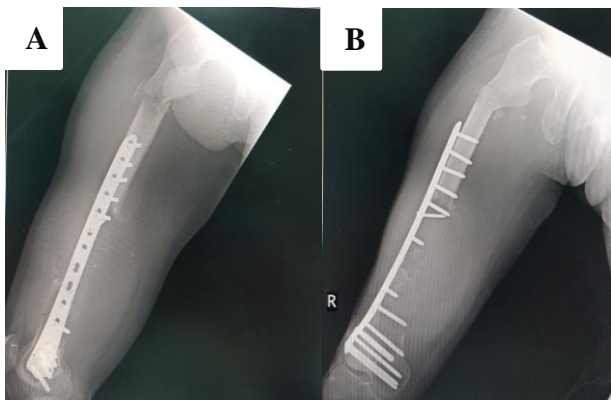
Plain radiograph of right femur shows fracture of distal femur with internal fixation. Lytic lesion involving the shaft and extend to proximal and distal part are observable. (A): Femur X-ray lateral view. (B): Femur X-ray AP view.
